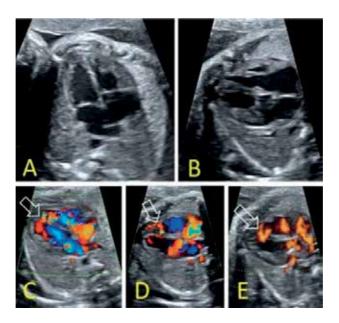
Multiple VSDs, apical and muscular, inapparent in gray-scale evaluation. (A): Apparently normal ventricular septum in apical and (B): lateral four-chamber view. (C–E): Muscular VSDs diagnosed using color Doppler in lateral four-chamber view—open arrows.
